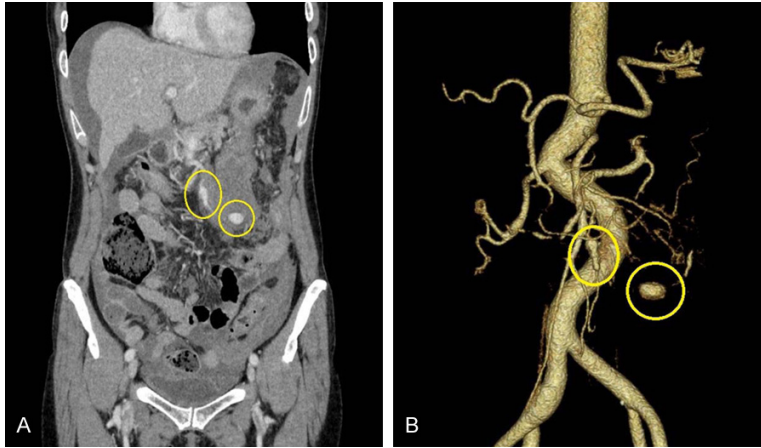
Abdominal CT with contrast enhancement (A) and 3D-magnetic resonance angiogram (MRA) (B). Two aneurysm-like lesions involving the middle colic artery (circled) were demonstrated.
